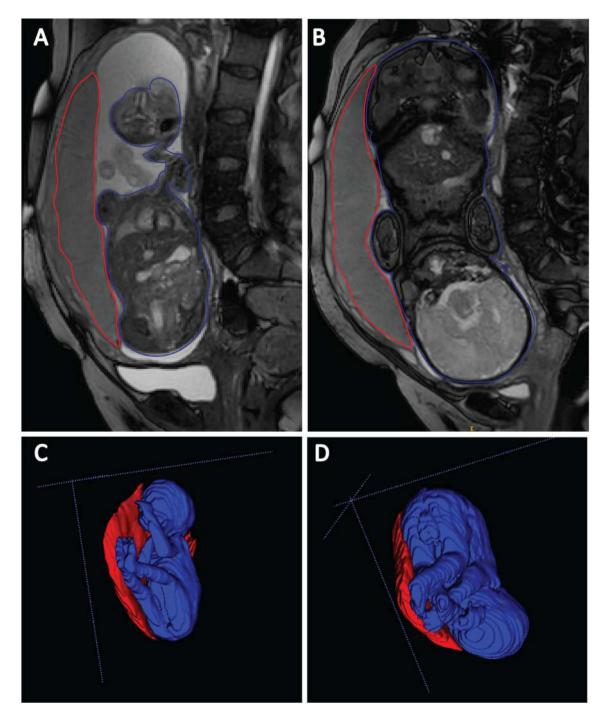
Example MRI images with tracings and 3D models at gestational week 27 (A and C) and gestational week 37 (B and D). The placenta is shown in red, the fetus in blue. In this pregnancy, the placental to fetal ratio decreased from 0.76 at gestational week 27 to 0.33 at week 37.
